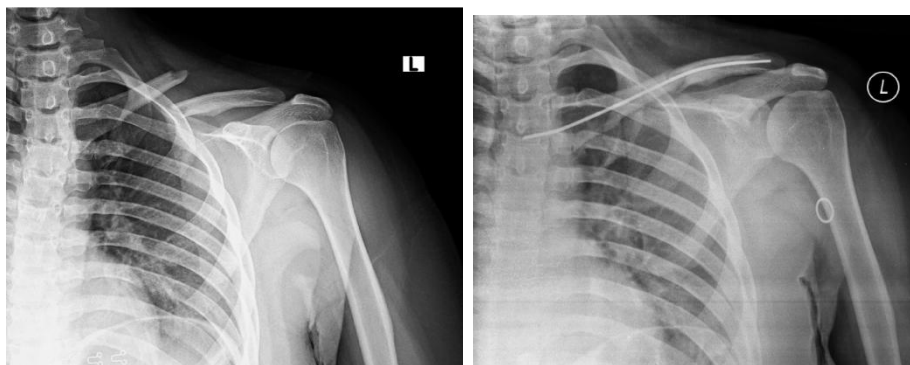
Pre-Operative & 5 month follow up X-Rays of a 45-year-old male patient with AO Type B1 Right Midshaft clavicle fracture
